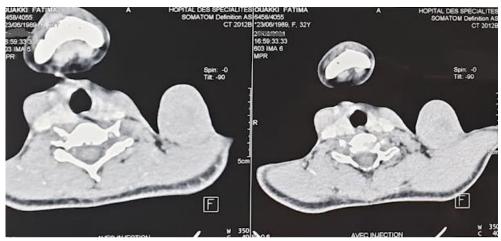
Cervicothoracic CT showing the presence of a tissue mass in the supraclavicular region without infiltration of the underlying muscle
